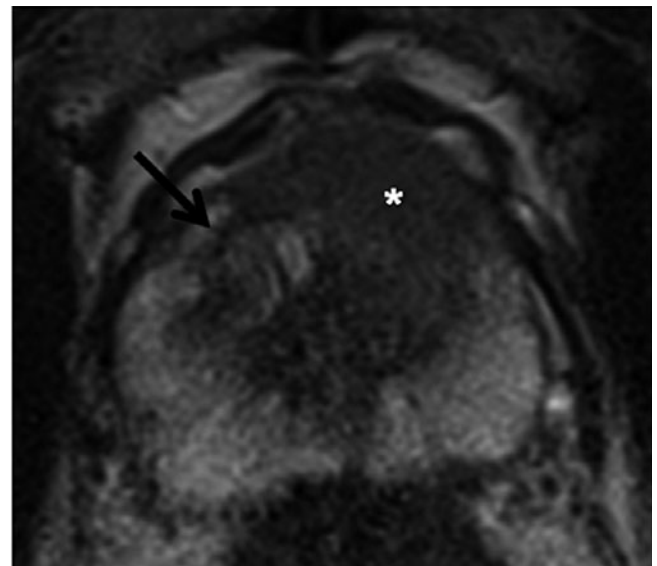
Prostate cancer of the transition zone: Axial T2-weighted turbo-spin-echo (TSE) with homogeneously hypointense lesion ventral left paramedian (*). Whereas the benign hyperplastic nodule has a distinct hypointense border on the right in the transition zone (arrow), the border around the focus is unclear (erased charcoal sign). There is a ventral protrusion in the contour of the cancer
